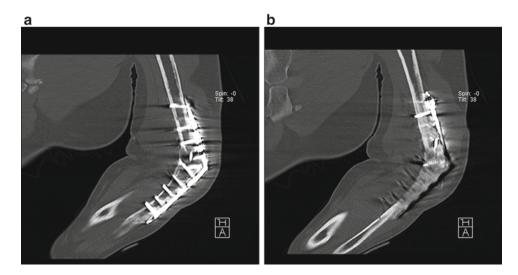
Two representative lateral CT scan images (a, b) showing healed fusion
